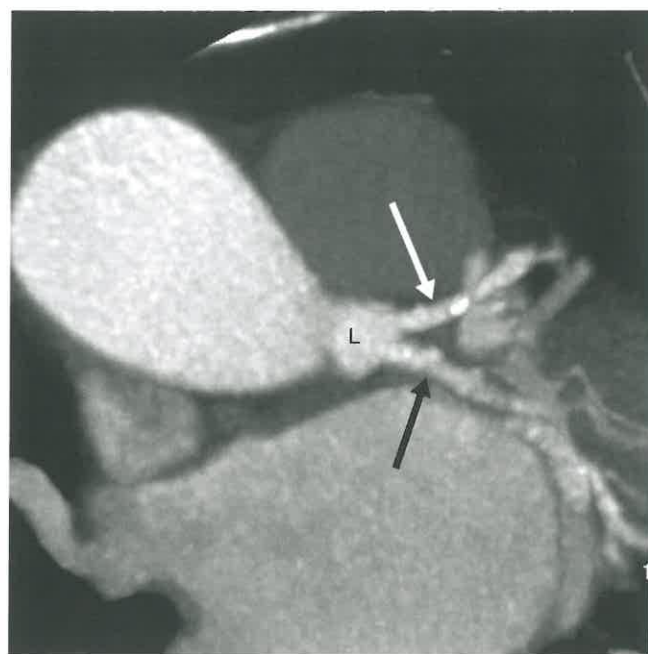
Absent Left Main Coronary Artery. Axial oblique image from a coronary CTA shows complete absence of the left main coronary artery. The left anterior descending (*white arrow*) and left circumflex (*black arrow*) coronary arteries arise directly from the left sinus of Valsalva (L). This is a rare but benign congenital variant.
